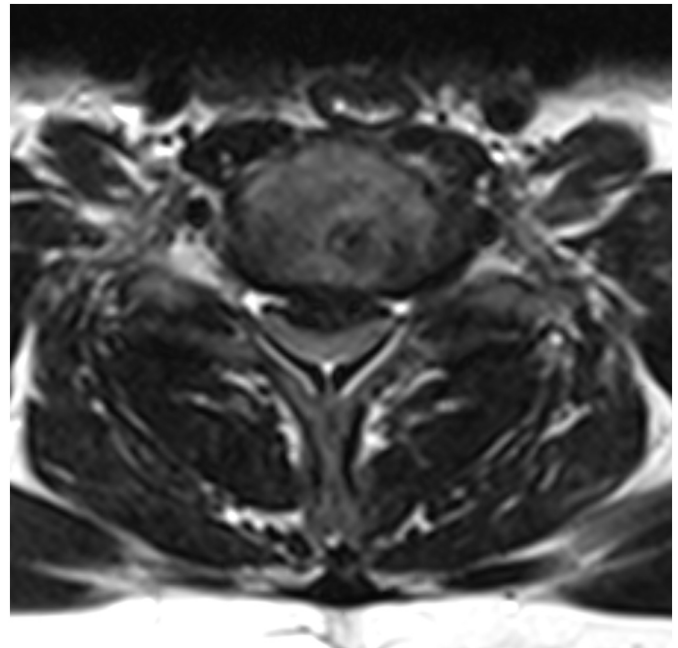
Preoperative MRI of the cervical spine, T2 axial sequence demonstrating intervertebral posterior disc herniation at the C6–C7 junction.
